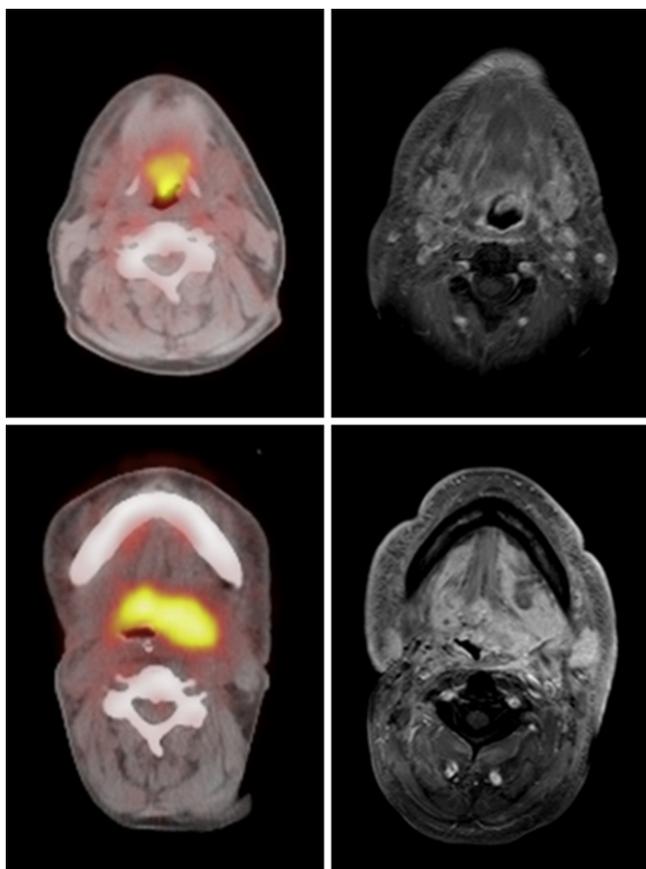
Four months post-radio-chemotherapy in patient 20, transaxial ¹⁸F-FDG PET/CT images demonstrate tumor recurrence in the vallecula and epiglottis (left upper) while MRI remains inconclusive (right upper). Recurrence is treated by laryngectomy and, 12 months later, transaxial ¹⁸F-FDG PET/CT images demonstrate a large submucosal tumor recurrence undetected at clinical examination (lower left), also detected on the MRI images (lower right).
